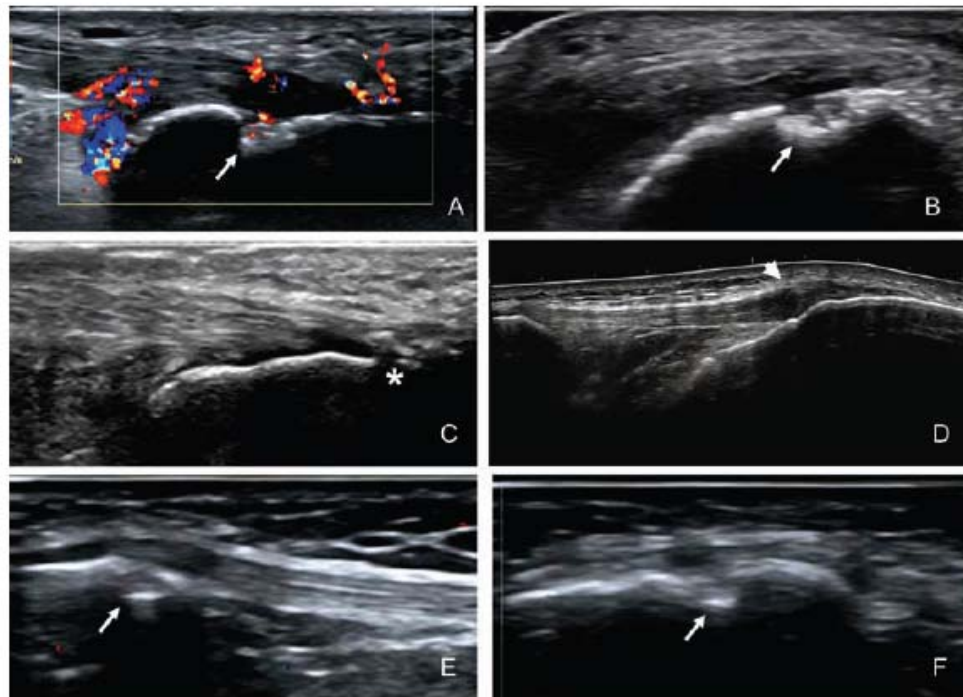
Ultrasonographic appearance of enthesal insertions. (A) Achilles entheses, longitudinal view, Doppler in bursa and tendon entheses, and erosion with Doppler signal (arrow). (B) Erosion, transverse view (arrow), same patient in image A. (C) Achilles tendon entheses, calcification grade II, longitudinal view (*). (D) Distal patellar entheses, longitudinal view, panoramic, abnormally hypoechoic (loss of normal fibrillar architecture) and thickened tendon at its bone attachment (arrow head). (E) and (F) Proximal patellar entheses insertion with an erosion (arrow), (E) longitudinal view and (F) short axis.
